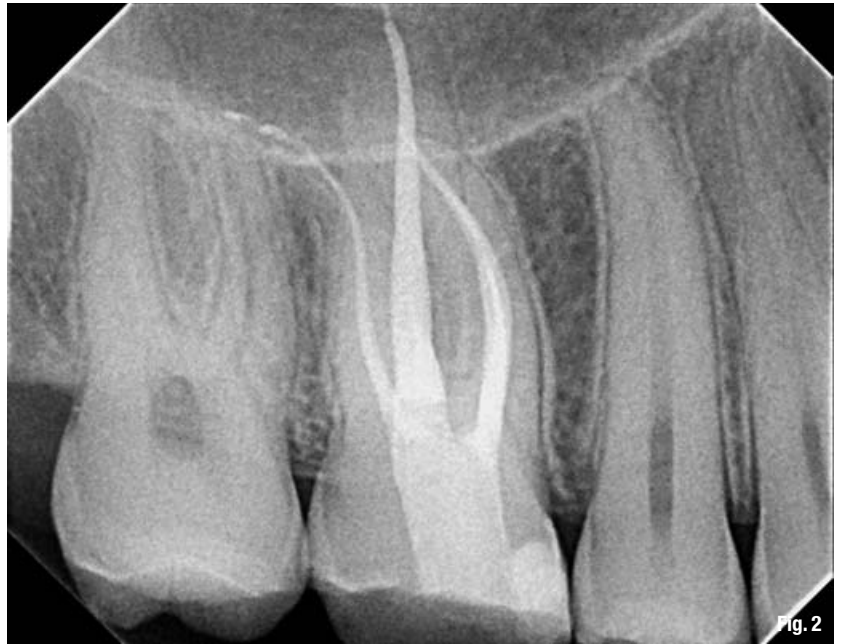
Post-op radiograph showing conservative coronal shapes, apically accurate fills, and an ideally cut access cavity with the mesial and distal access walls parallel to the mesial surface of the tooth.
